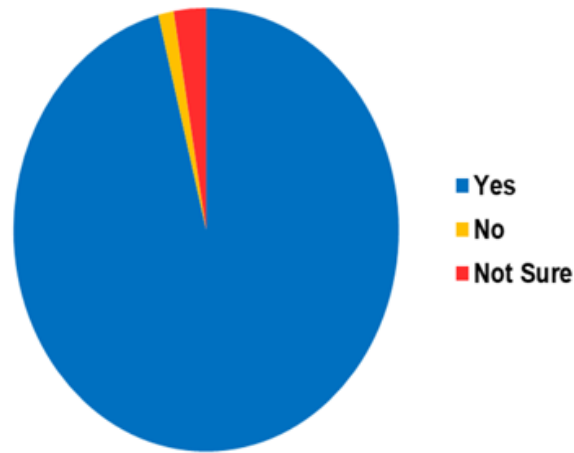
Radiographers' knowledge of the NAI acronym.
